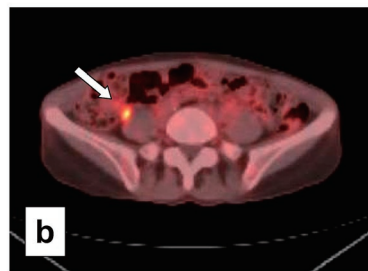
Metastasis in the right external iliac lymph node on 1st PET/CT imaging. a: coronary view, b: axial view, tumor: →.
